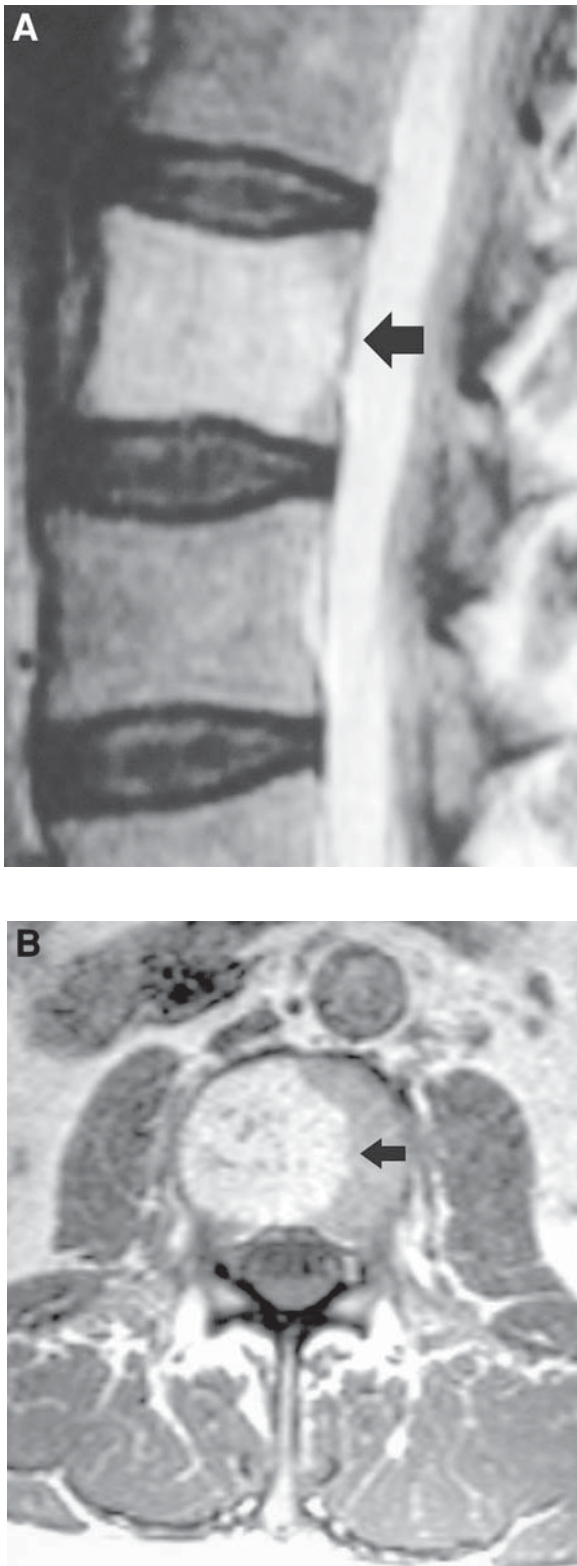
Vertebral hemangioma. Sagittal T2-weighted (A) and axial T1-weighted (B) images demonstrate the classic appearance and high signal of a hemangioma.
